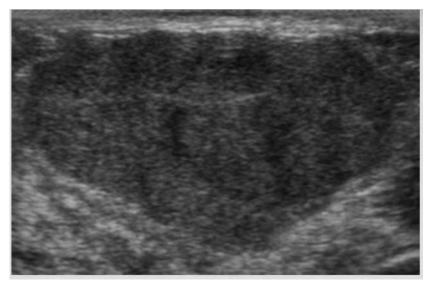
Ultrasound image of one of our patients showing a tissue lesion in the upper outer quadrant (QSI) of the right breast, oval in shape, with the long axis parallel to the skin and macrolobulated contours, classified as ACR4a.
